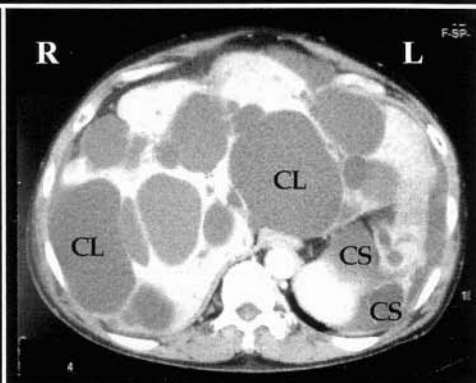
CT scan abdomen: cysts that appear as well-defined round or oval masses with low attenuation values similar to those of water. CL = cysts in the liver, CS = cysts in the spleen.
